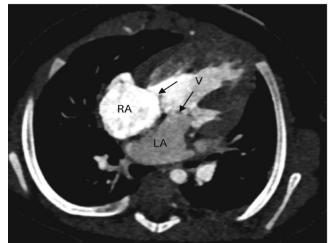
Cardiac CT axial view showing double-inlet ventricle with both atrioventricular valves (arrows) communicating with common ventricle. RA right atrium, LA left atrium, V common ventricle. (Kharouf and Adebo 2021).
